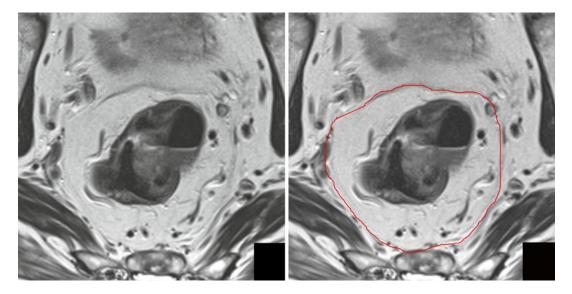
MRI showing circumferential resection margin (see red line)
